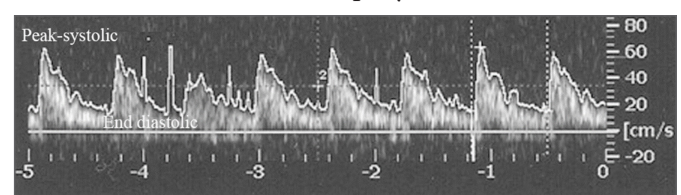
Representative sonography of ophthalmic artery 77x22mm (300 x 300 DPI)
